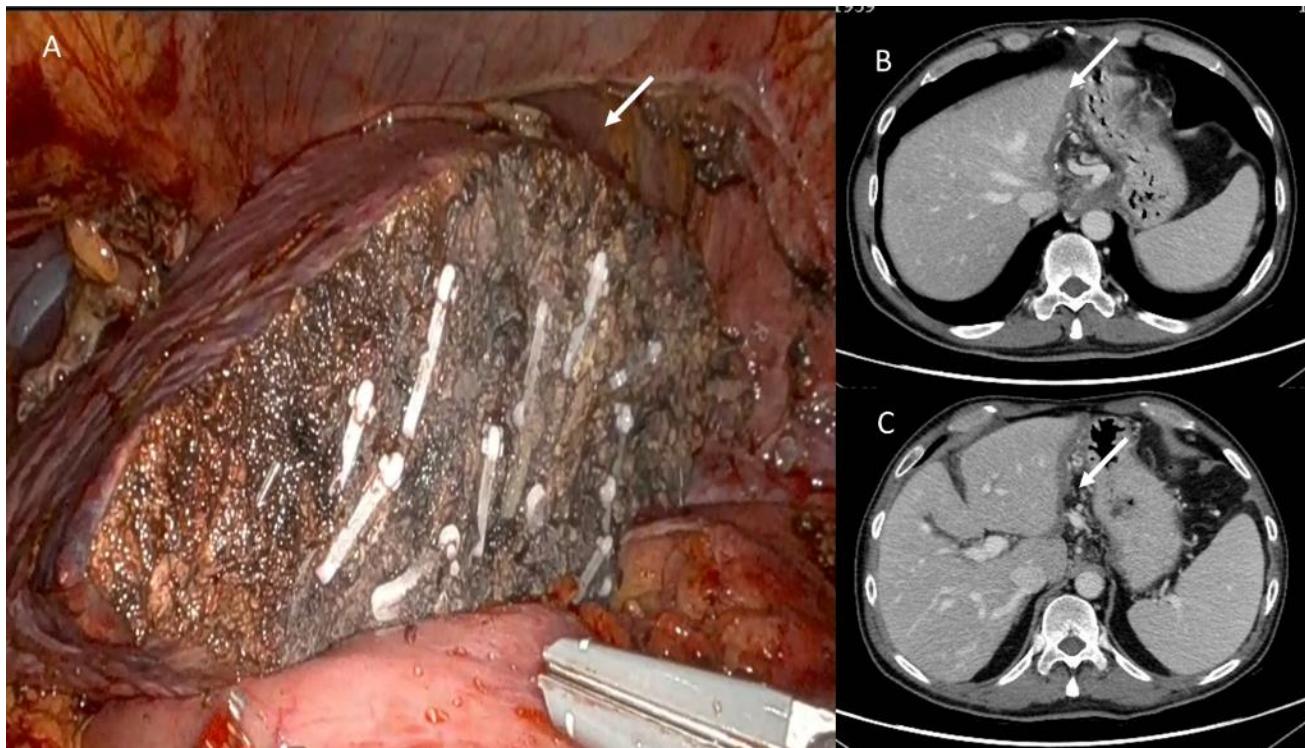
Robotic Anatomical S2 segmentectomy in patient with HCC (A). In (B,C), CT assessment at 3 months follow-up: arrows show scar tissue.
